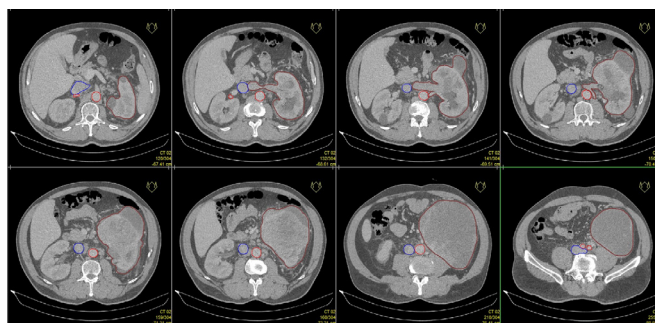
Preparation of digital three-dimensional model of the kidney with the tumor and vessels, based on the patient's computed tomography images.
